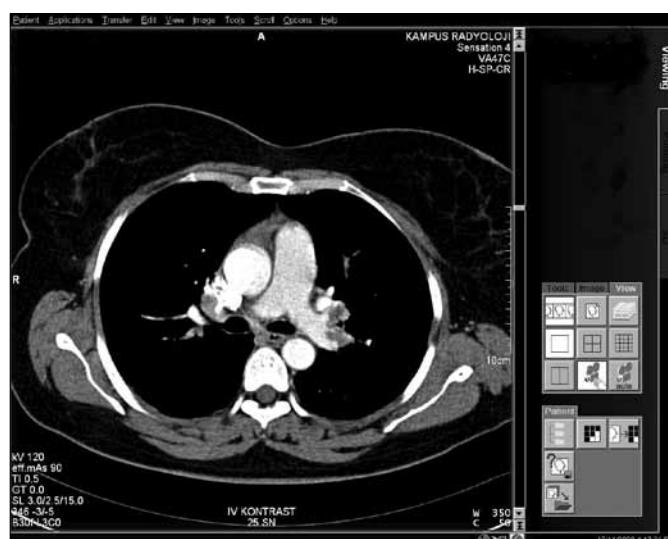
Chest CT showed massive filling defects in bilateral pulmonary arteries
